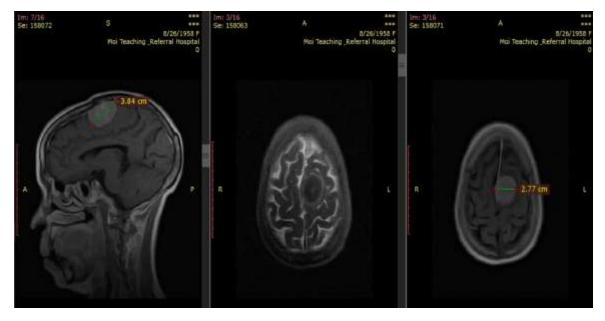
MRI brain T1 and T2 imaging, Coronal, axial and sagittal images of a 54-Year-old Male showing frontoparietal lesion which is heterogenous in all the sequences and ring enhancing past T1 with gadolinium contrast with perilesional edema. This was conformed to be glioblastoma.
